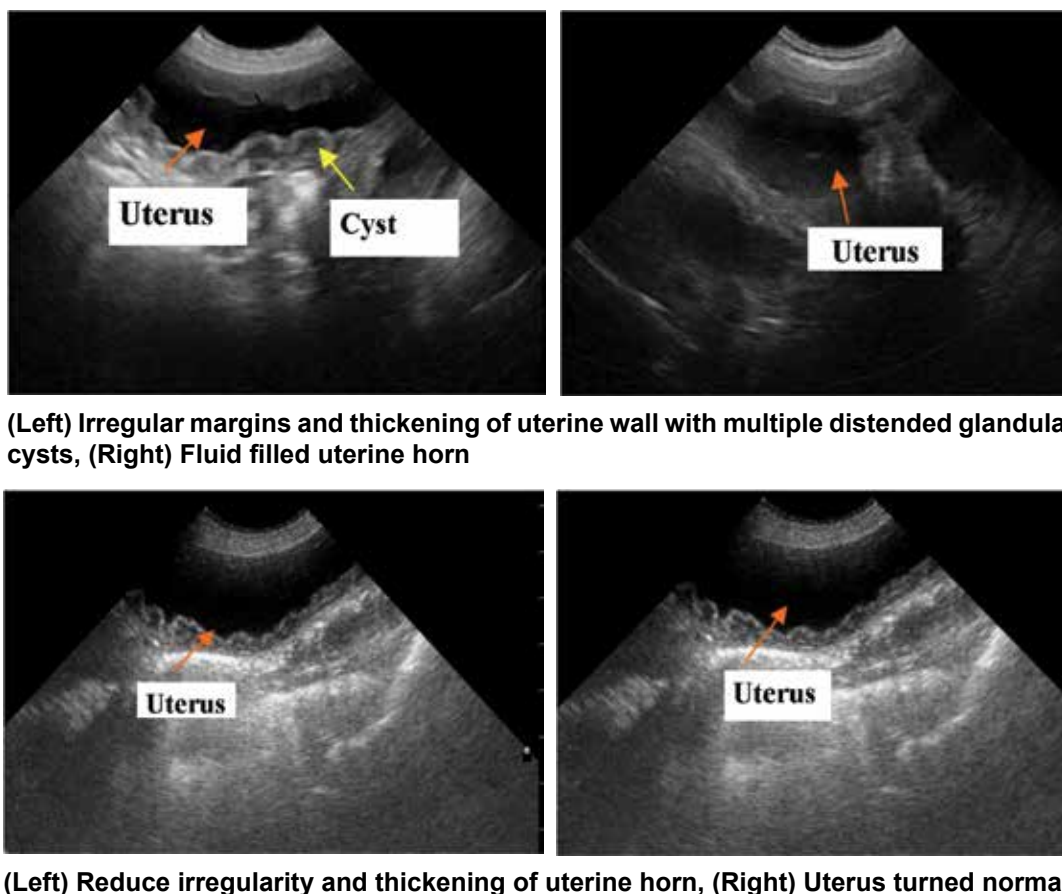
Ultrasonography of a case of cystic endometrial hyperplasia-open pyometra in a bitch during pre- (upper panel) and post-treatment (lower panel) period
